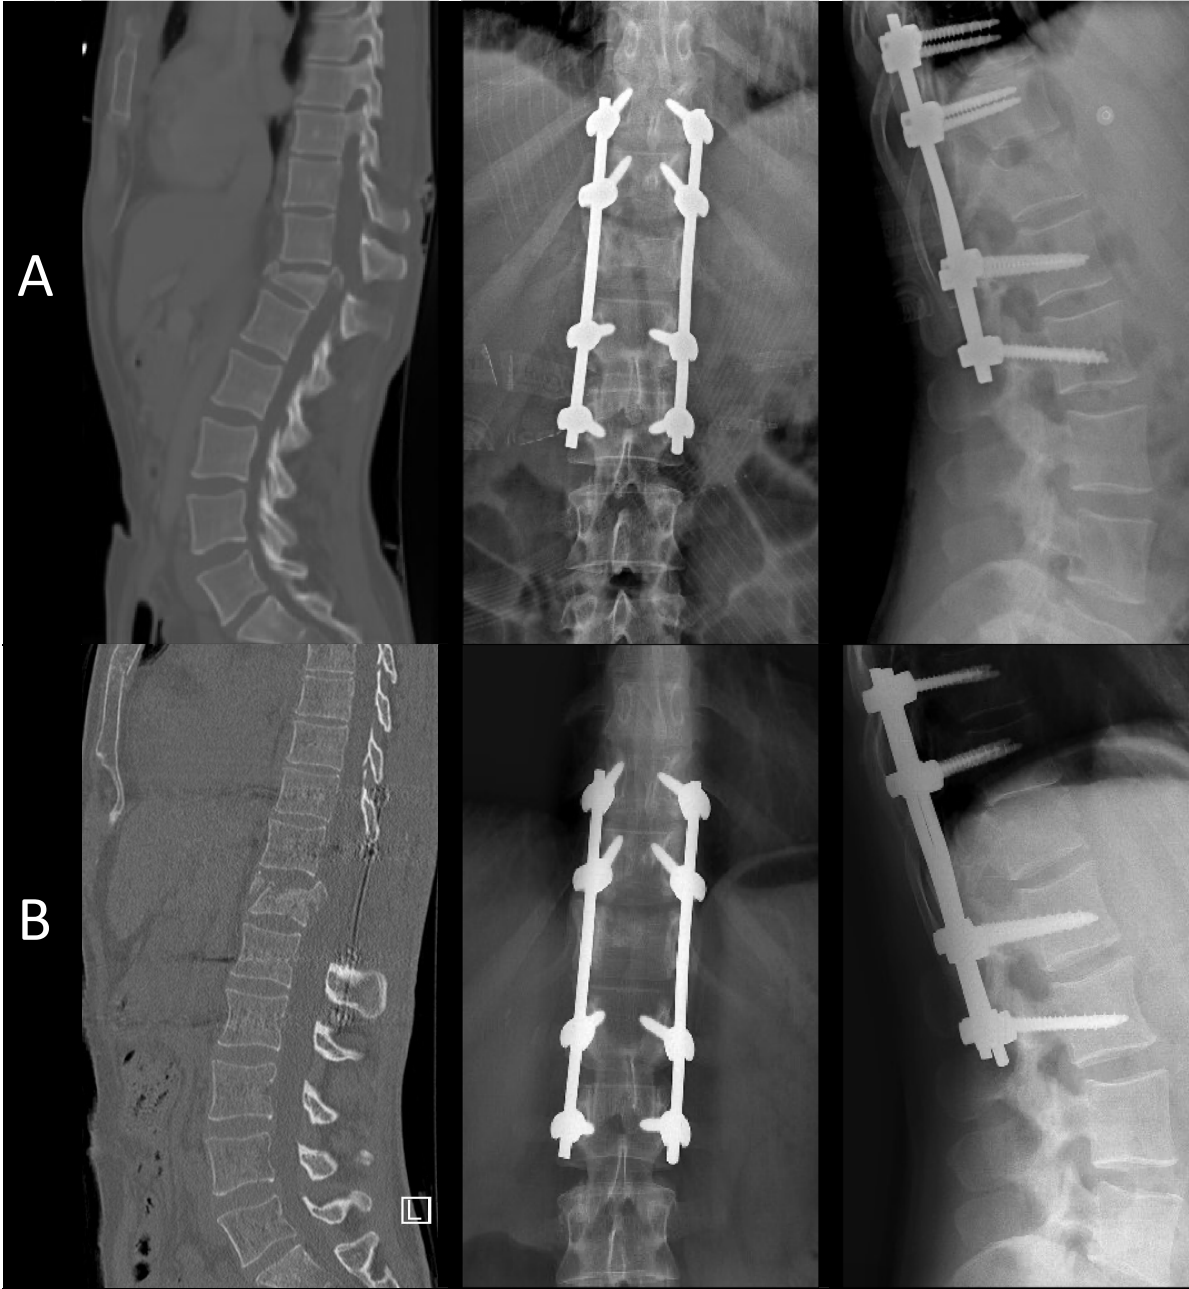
A-B: A) Preoperative sagittal CT scan (left side) showing the fracture, and early postoperative (middle and right side) x-ray check demonstrating a good correction. B) 2 years postoperative sagittal CT scan (left side) and postoperative x-ray check (middle and right side) demonstrating the absence of bony consolidation as well as a slight loss of correction.
